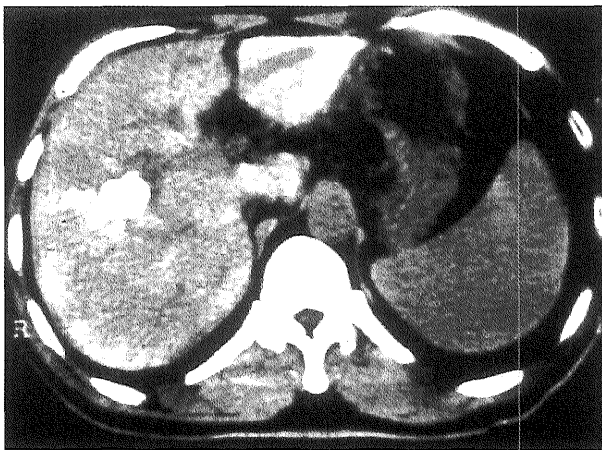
CT on admission: A high density area, 20 mm in diameter, was found in segment VIII of the right liver with Lipiodol accumulation. Simultaneously, splenomegaly was also demonstrated.
